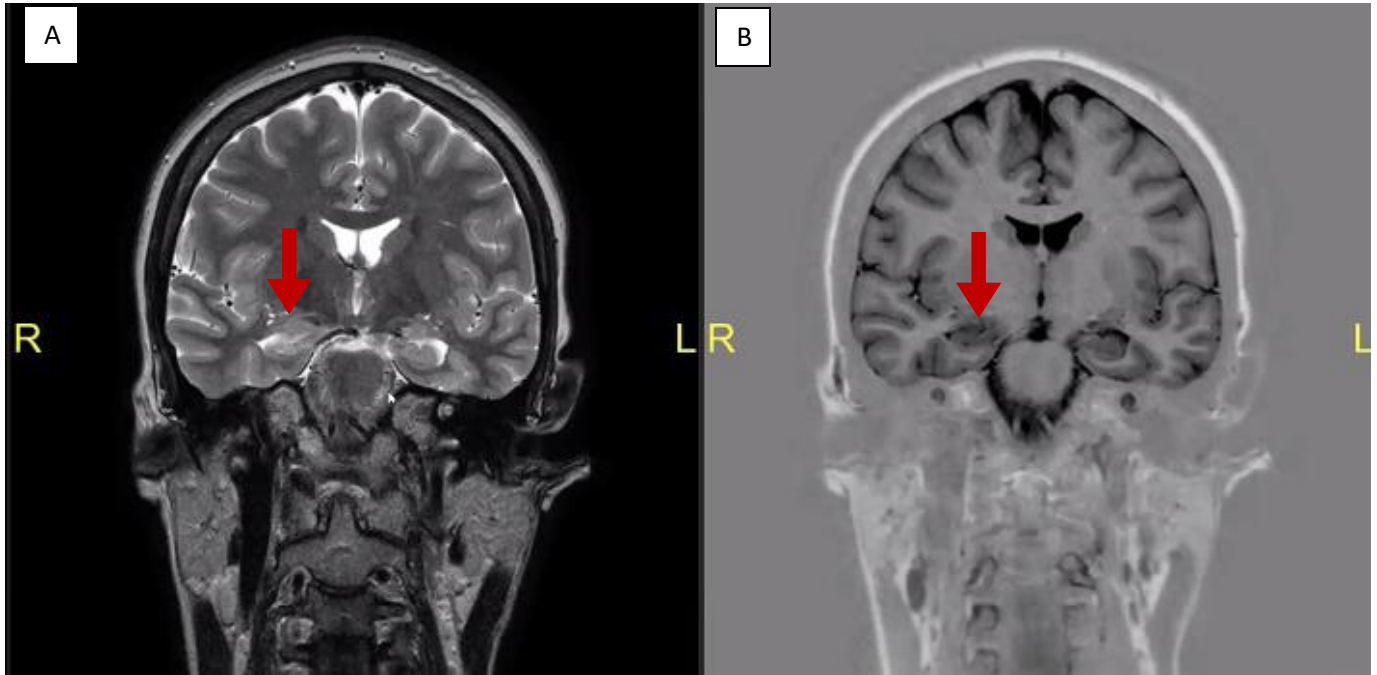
Coronal T2-weighted, and T1-weighted inversion recovery brain MRI (Panel A and B respectively) of a study participant showing evidence of right-sided hippocampal atrophy (indicated by arrows).
